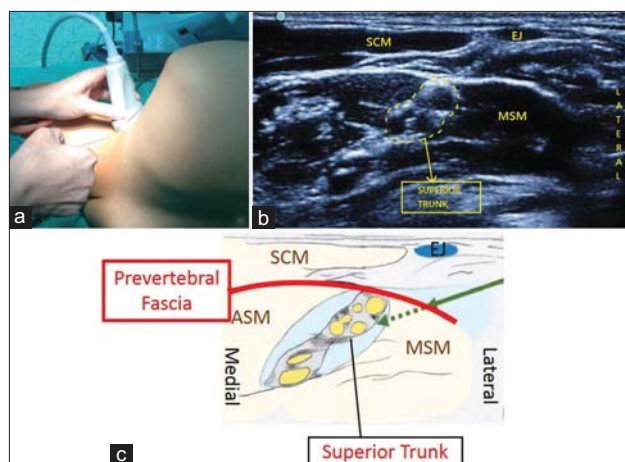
The single-penetration double-injection approach to peripheral nerve block for the patient (a and b). The patient was placed in the lateral decubitus position with the right side up (a). Preinjection sonogram is showed as (b). With the long axis of the transducer oriented along the visual axis, the needle is inserted in-plane lateral to sternocleidomastoid toward the superior trunk. A sketch is made corresponding to the post-injection sonogram (c). The needle is shown by the green arrow in the sketch. Single-penetration double-injection approach includes one injection posterior to the superior trunk and the other over middle scalene muscle. After spreading around the superior trunk (from the dotted green needle tip), the needle is then pulled back to place its tip (the solid green arrow) over the prevertebral fascia above middle scalene muscle. Blue shaded area indicates the spread of injectate from the green needle tip. EJ: External jugular vein, MSM: Middle scalene muscle, SCM: Sternocleidomastoid muscle, ASM: Anterior scalene muscle
